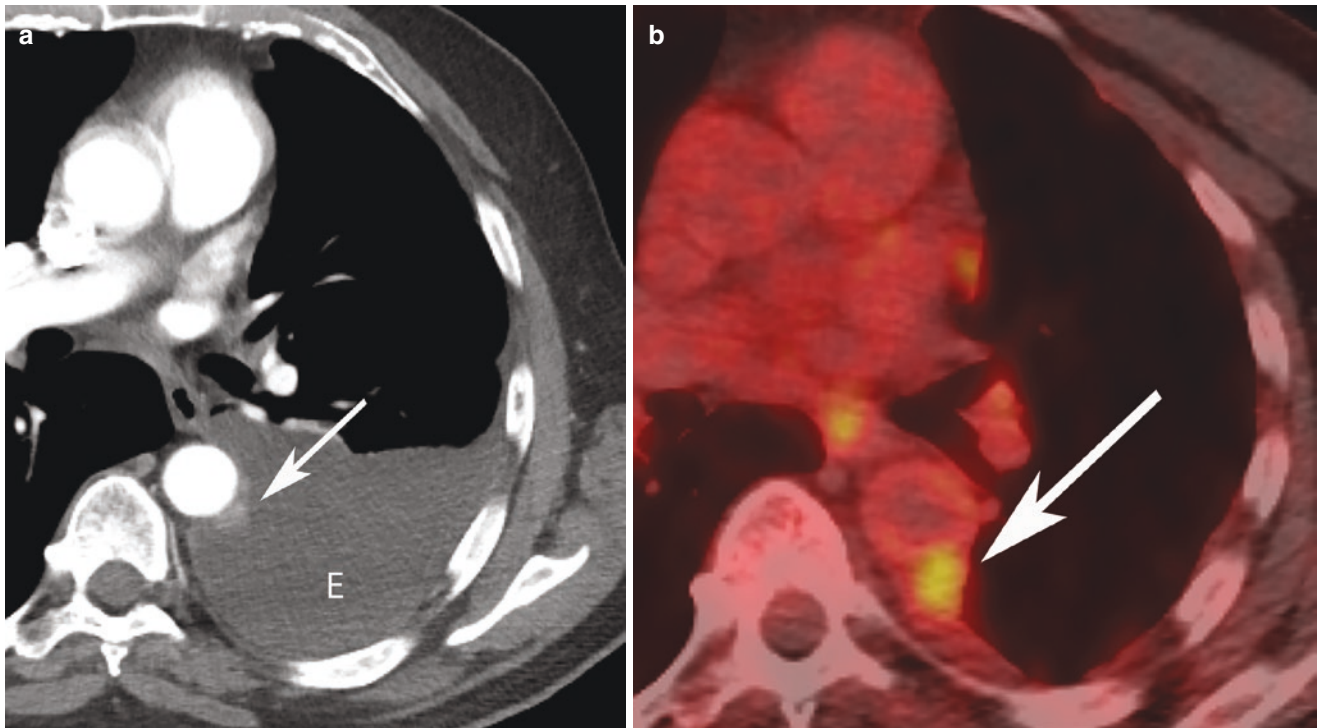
(a) Contrast-enhanced axial CT demonstrates a moderate left pleural effusion (E) with a small area of nodular pleural thickening (arrow) adjacent to the descending thoracic aorta; (b) axial FDG-PET/
